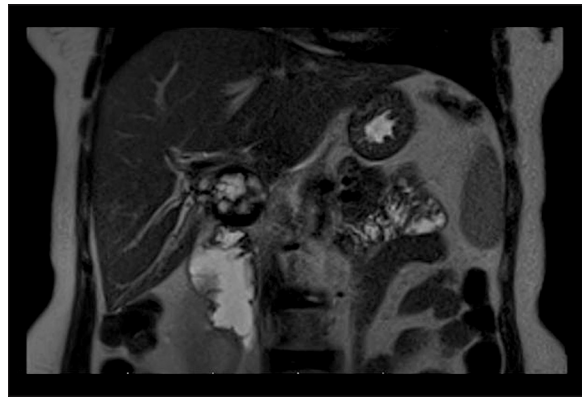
MR imaging shows a heterogeneous hyperintense lesion with a low signal in its periphery and mildly dilated adjacent intrahepatic bile ducts at the level of segment V on coronal T2 fat-suppressed sequences.
